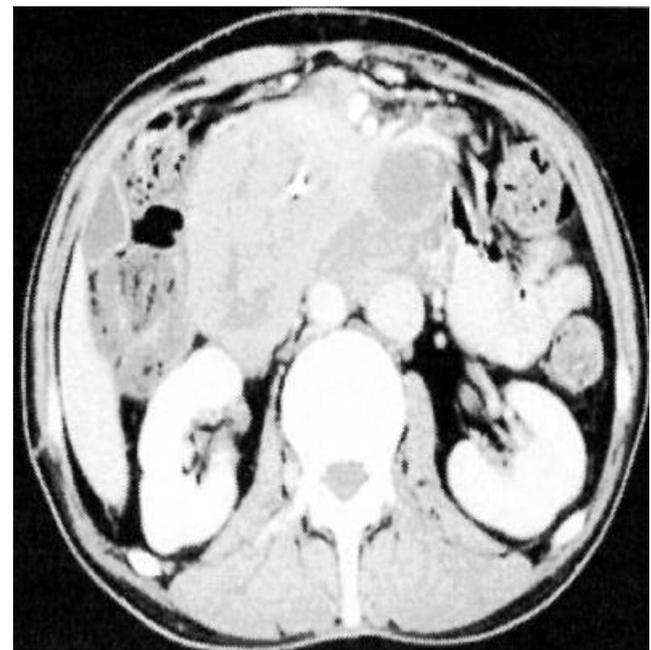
Enhancement CT was heterogeneous (a stent insertion).
